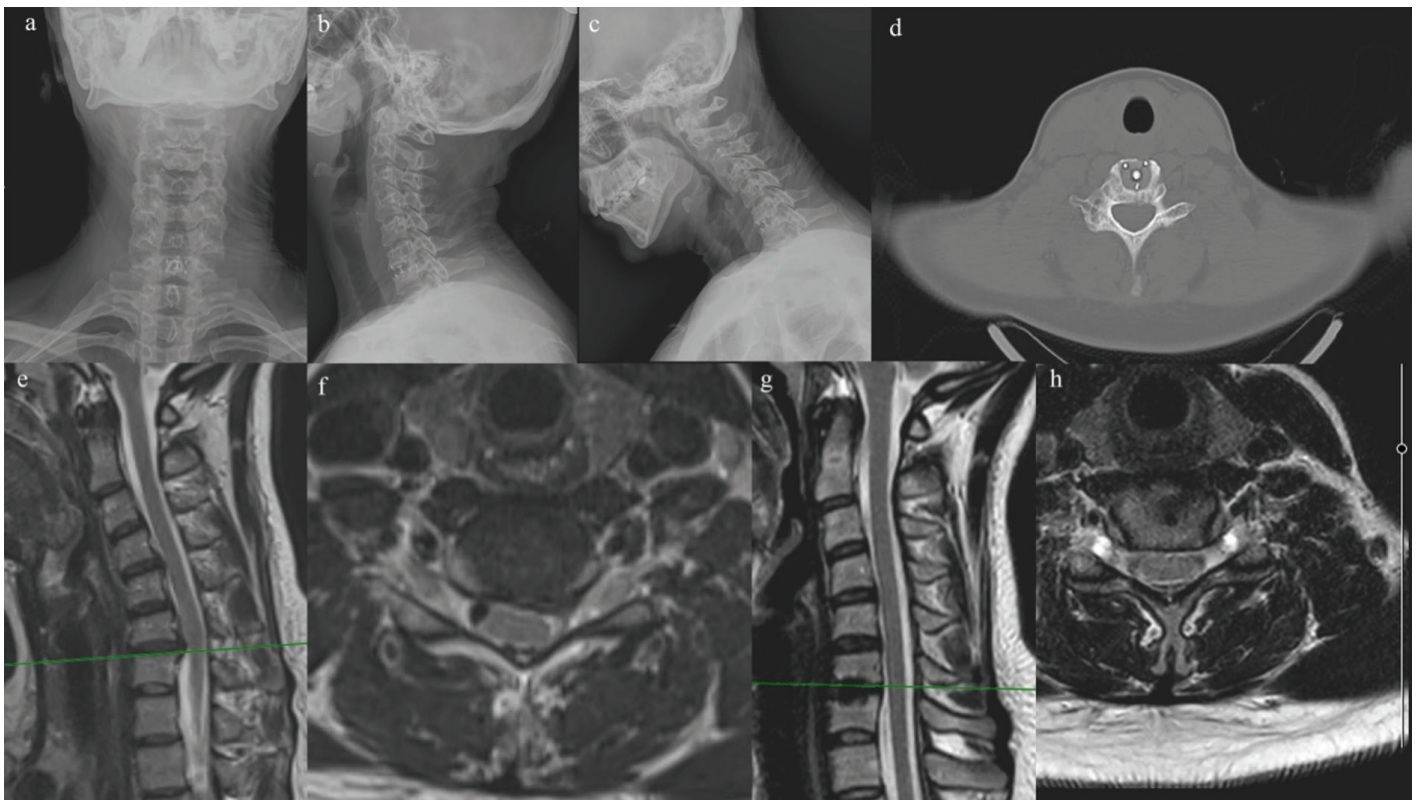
Radiological images of a 37-year-old female patient with left disc herniation at the C6-7 level: AP (a) flexion (b) and extension (c) positions in direct cervical radiographs. PEEK prosthesis in cervical axial plane computed tomography (d). Disc herniation at the C6-7 level causing spinal cord compression on sagittal plane MR image (e). Left paracentral disc herniation on T2 section in axial plane (f). One year later, on sagittal MR T2 sequence, hypointense changes at the C6-7 level due to PEEK prosthesis (g). Decompressed spinal cord and radix on T2 MR slice in axial plane (h).
